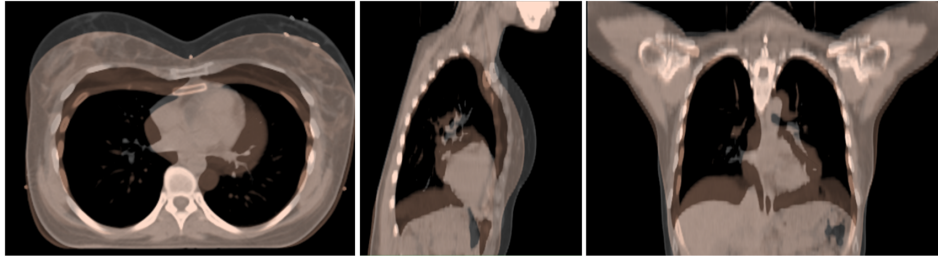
CT images of a patient are shown as examples in DIBH (gray) and FB (pale orange) conditions, presented in three axial (left), sagittal (middle), and coronal (right) views.
